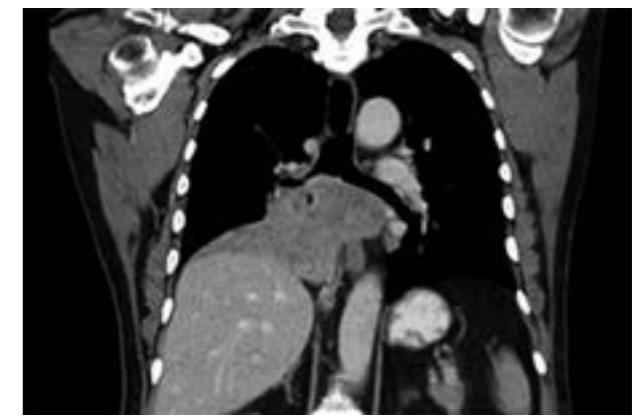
CT scan. Tumor infiltration in the subcarinal region extending to the right costophrenic angle. Atelectasis of the right lung
